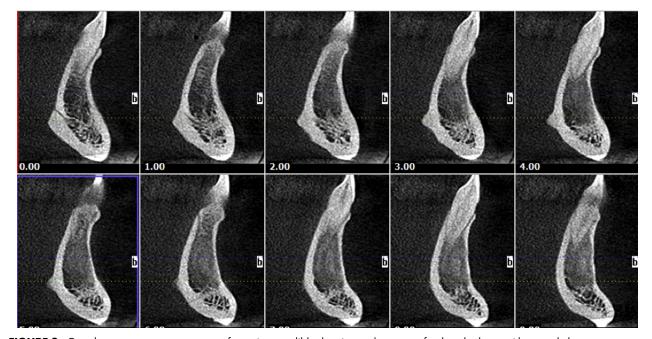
Cone-beam computer tomograms of anterior mandible showing replacement of trabecular bone with ground-glass appearance. Saba, Tocaciu, and Subramanian. Primary Xanthoma of the Mandible. J Oral Maxillofac Surg 2018.
